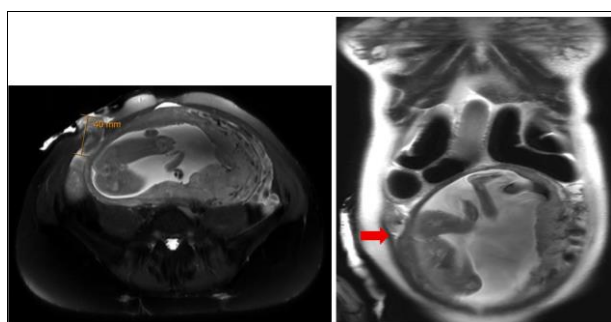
A) Axial and B) Coronal MRI image showing focal point of extrinsic compression by the uterus (red arrow), measuring 4cm from the ileostomy
